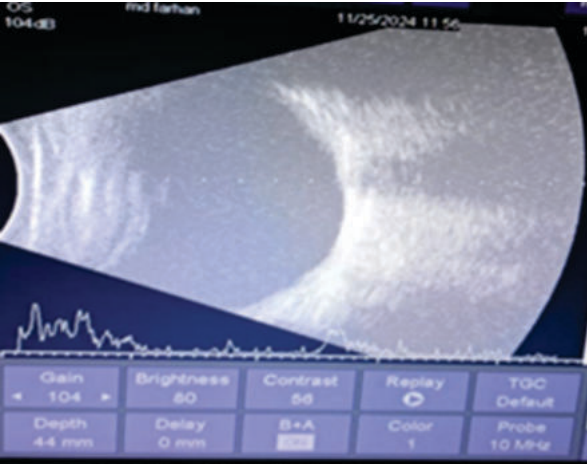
B-scan Ultrasonography of the Left Eye Showing an Attached Retina with Normal Vitreoretinal Interface and no Evidence of Posterior Segment Pathology.
